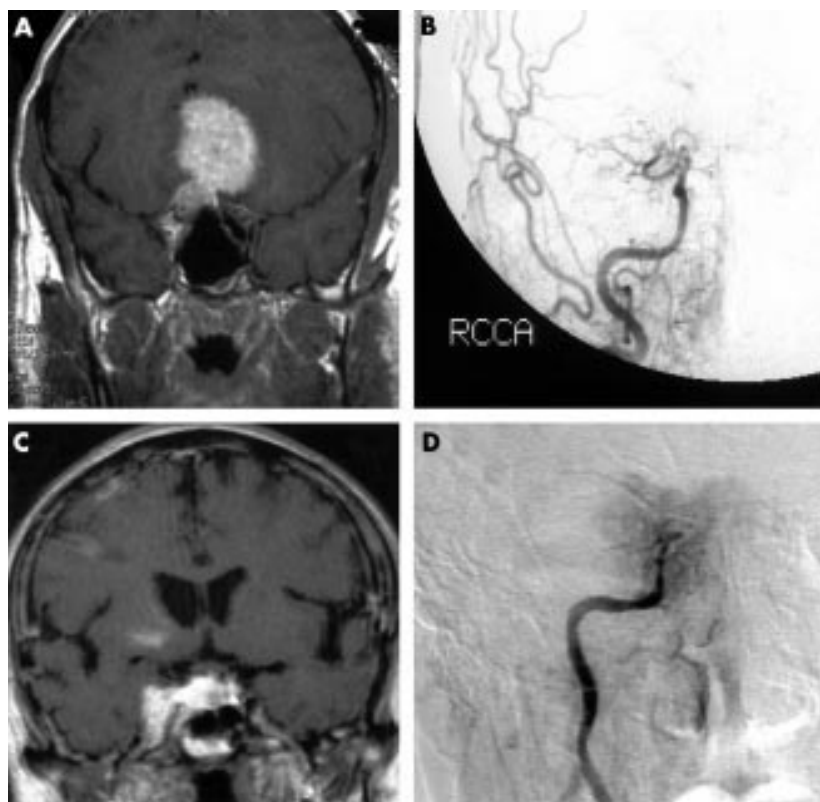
(A) Coronal T1 weighted MRI with gadolinium demonstrating a meningioma encasing the internal carotid artery (ICA) within the right cavernous sinus. (B) Cerebral angiography with right common carotid artery (CCA) injection demonstrating occlusion of the right ICA and radiographic blush from the surrounding meningioma. (C) Coronal T1 weighted MRI with gadolinium demonstrating a meningioma encasing the right ICA at the apex of the right orbit. (D) Cerebral angiography with right CCA injection demonstrating virtual occlusion of the distal right ICA.
